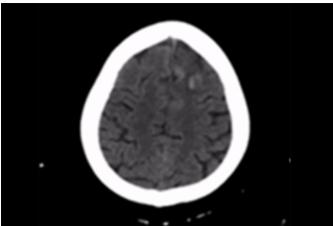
CT of the head showing interval development of left frontal haematoma.
